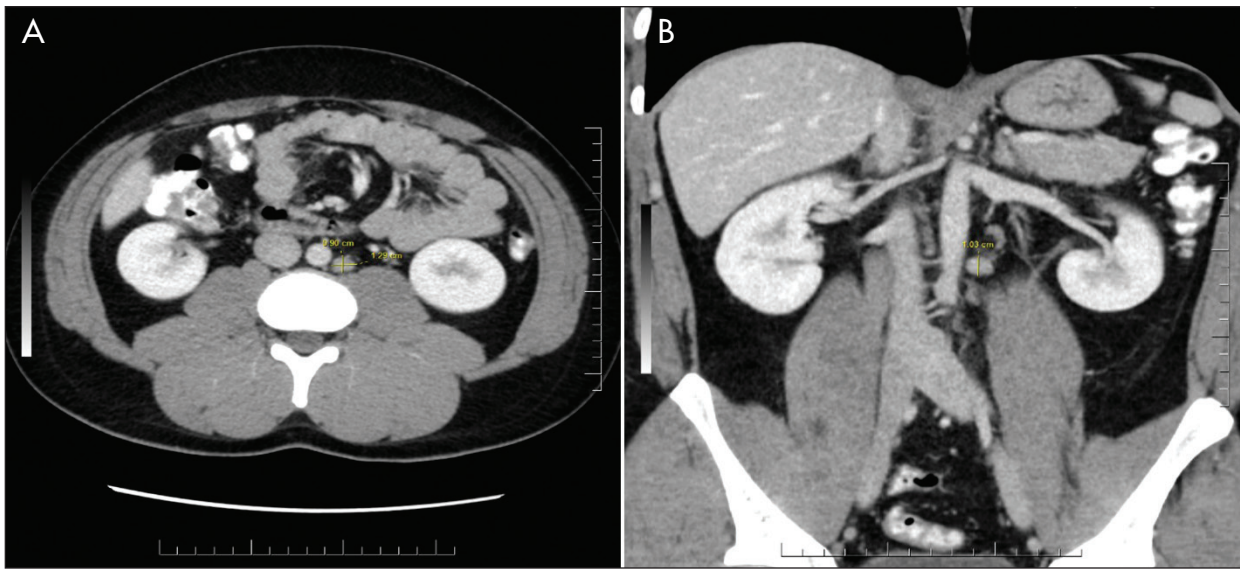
Case 1: Stage 1/2A seminoma. Computed tomography demonstrating 1 cm node in left para-aortic region.
